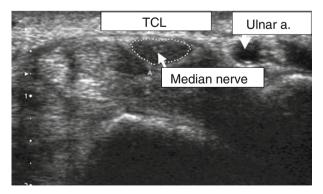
Ultrasonographic imaging. Cross section of the carpal tunnel contents. Median nerve size shown
